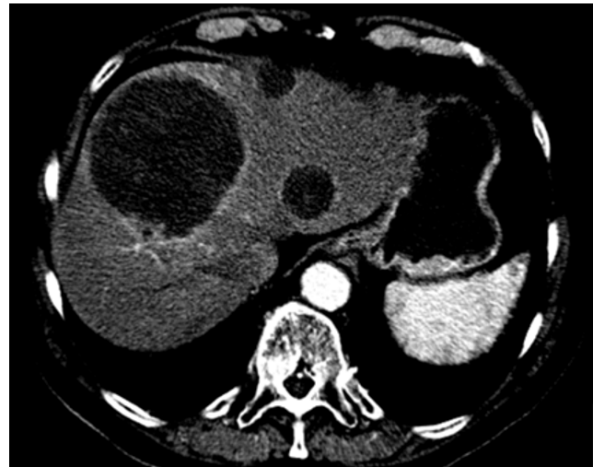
CT images before and after TACE (the same case as in figure 6). The HCCs are indicated by arrows.
